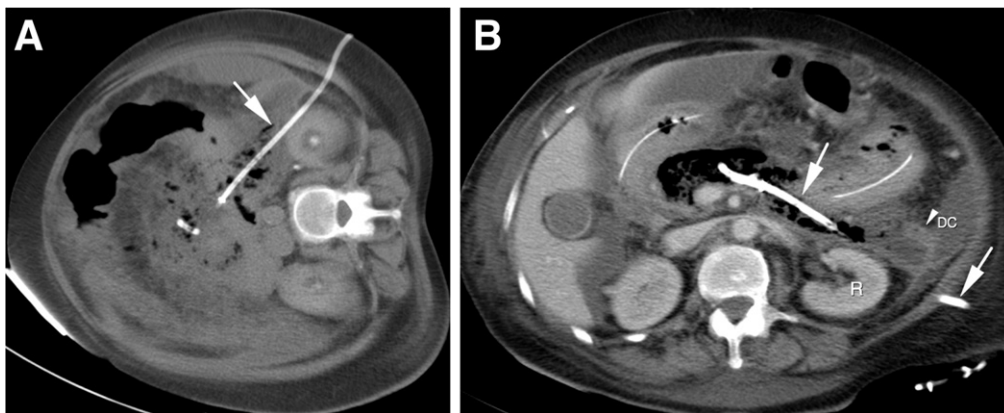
PCD: a 55-year-old woman with infected necrotizing pancreatitis (same patient as in Figure 2). Axial CT (A) performed in right decubitus position for optimal retroperitoneal positioning of a 12F percutaneous drain (arrow) via the left flank. Successive follow-up CT (B) reveals reduction in size of infected pancreatic collection, with PCD centrally positioned via the left retroperitoneal route (between the descending colon [DC] and the right kidney [R]).
